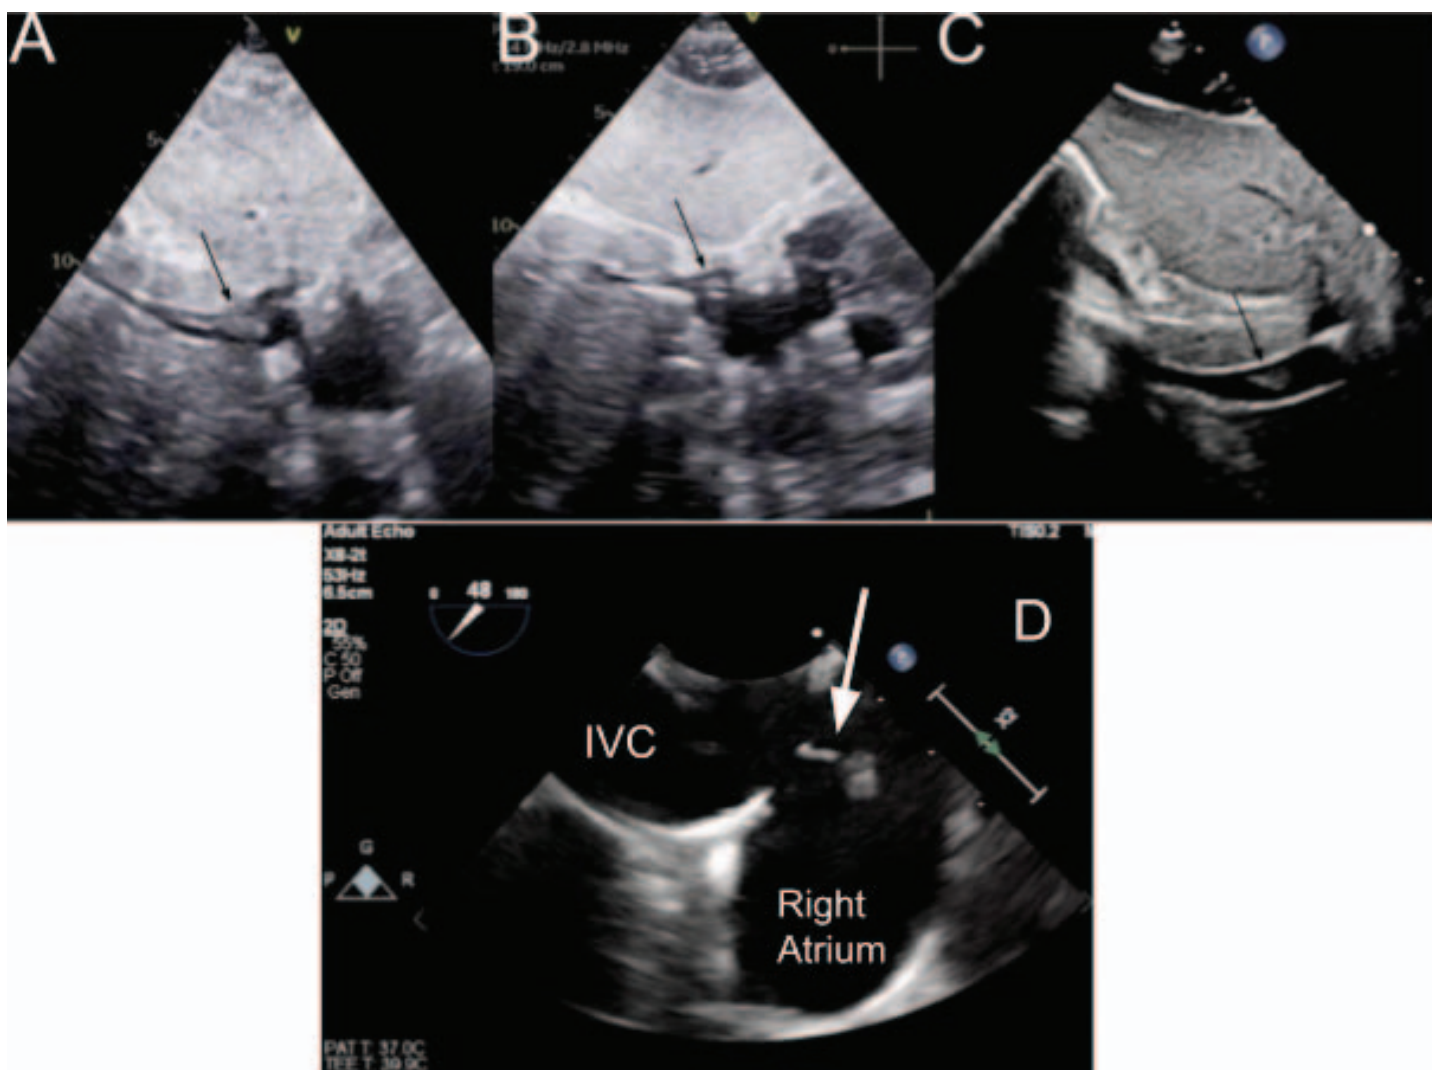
Echocardiograms showing IVC tumor thrombus evolution after systemic nivolumab and ipilimumab therapy. (A and B) Transthoracic echocardiogram showing tumor thrombus at 3 and 5 months after initiation of immunotherapy, respectively. Black arrow indicates presence of thrombus invasion of the IVC at the lower cavoatrial junction. (C and D) Transesophageal echocardiogram at 9 months post chemotherapy still displaying thrombus at lower cavoatrial junction, as indicated by black arrow in (C) and white arrow in (D). IVC, inferior vena cava.
